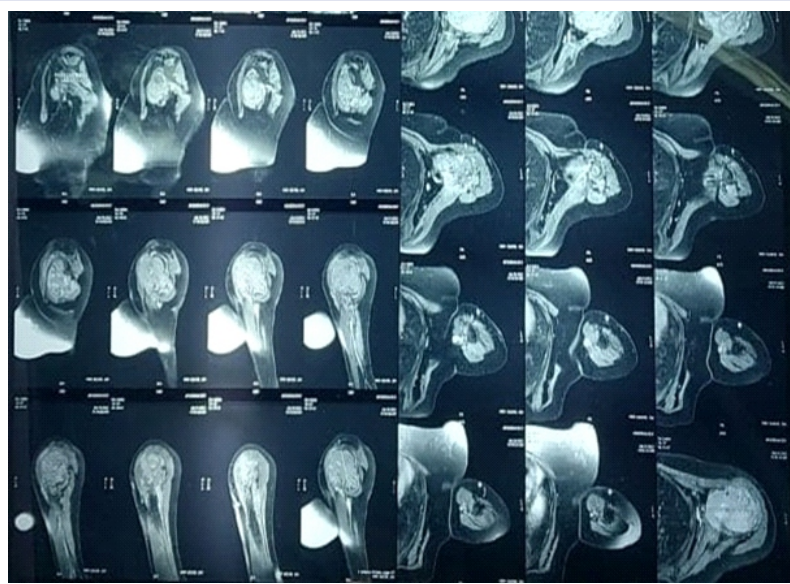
MRI SHOWING FEATURES CONSISTENT WITH GIANT CELL TUMOR
